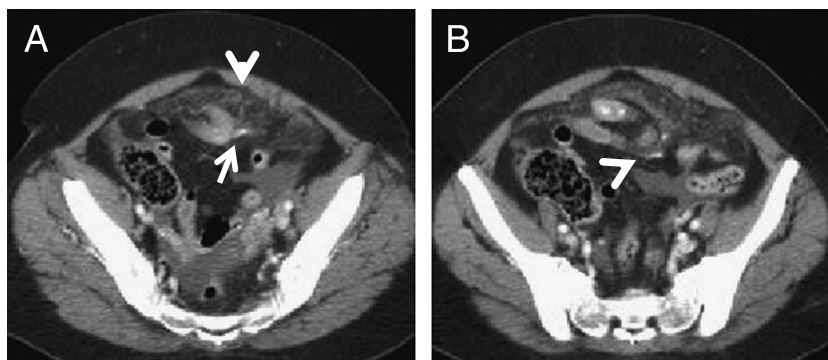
Spontaneous small bowel perforation in a 39-year-old man with the diagnosis of small bowel lymphoma on chemotherapy. Axial CT images of the abdomen at different levels after oral and intravenous contrast administration show contrast leak from a segment of small bowel (arrow) with associated mesenteric and omental fat stranding (arrowhead). Note also free contrast in the peritoneal cavity (arrow in B).
